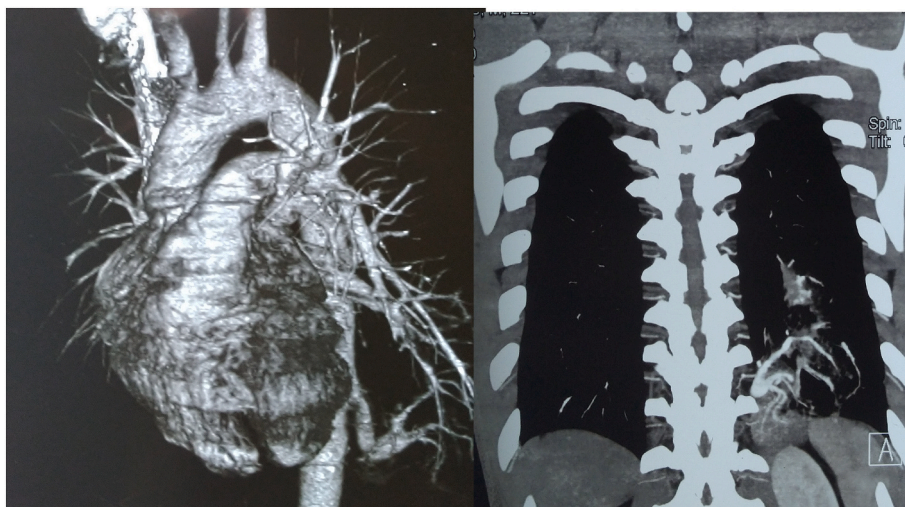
CT angiogram showing aberrant arterial supply (arrow) to lower lobe from distal descending thoracic aorta.
